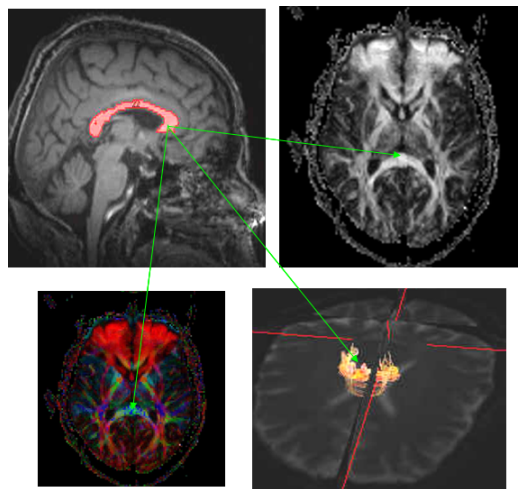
Corpus callosum correspondence in the human's brain modalities: MRI (top left), fractional anisotropy (top right), directional water diffusion (bottom left), CAT scan (bottom right).
